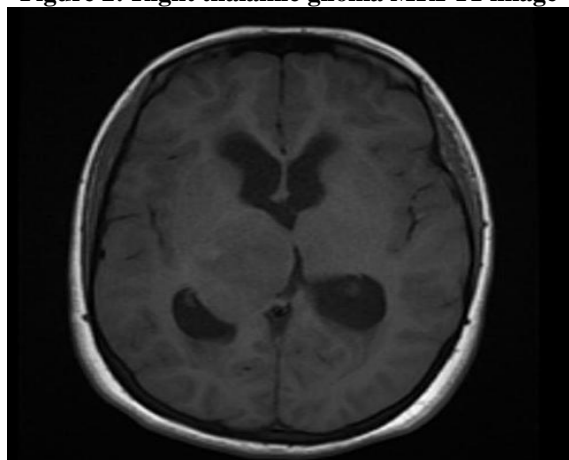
Right thalamic glioma MRI FLAIR image
